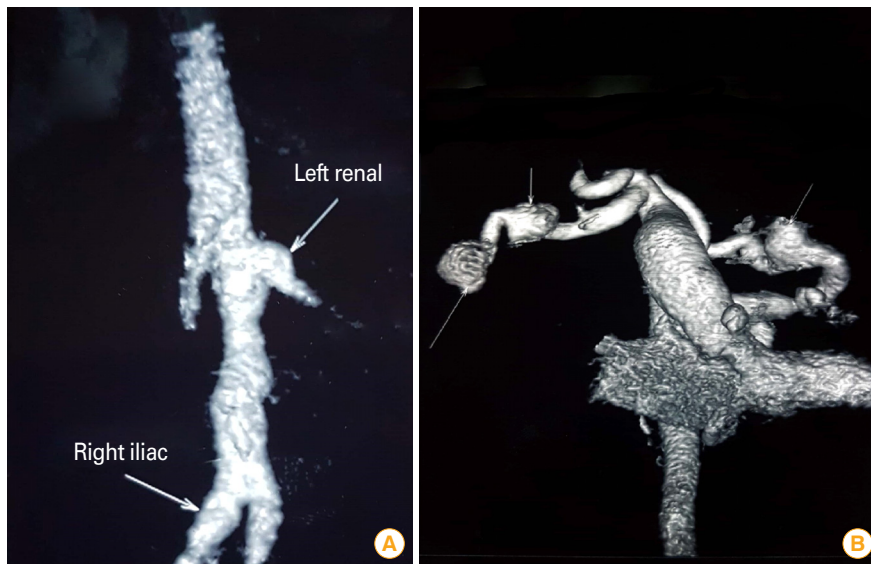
(A) Computed tomography (CT) angiogram showing left renal and right iliac arteries aneurysms (arrows). (B) CT angiogram showing bilateral subclavian arteries aneurysms (arrows).
